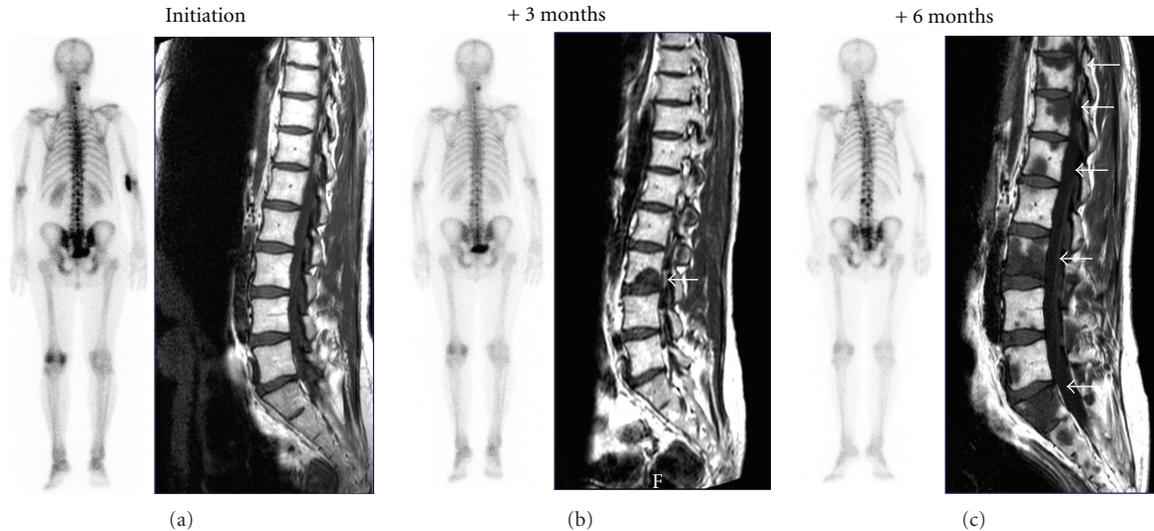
Consecutive series of three ^{99m}Tc bone scans (BS) and MRI acquired three months apart on a patient included in a clinical trial designed for M0 CRPC. Only the third BS is adjudicated as positive by the central review although he was already progressive on MRI at the second metastatic workup.
